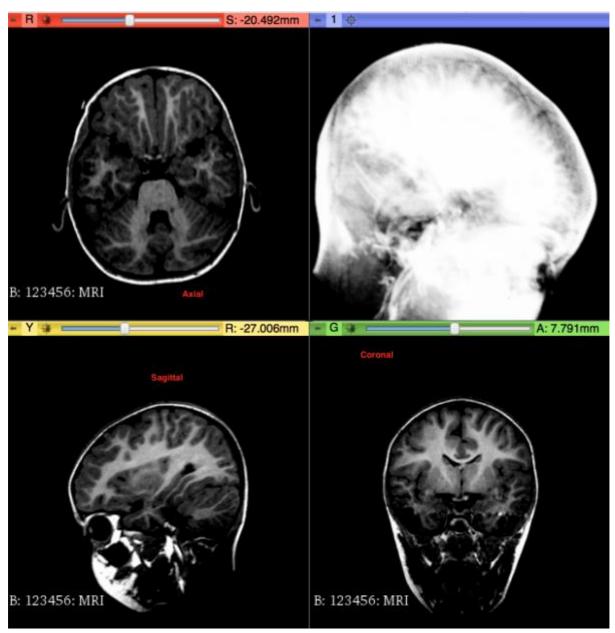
MRI MIP with adjusted contrast in 3D slicer
